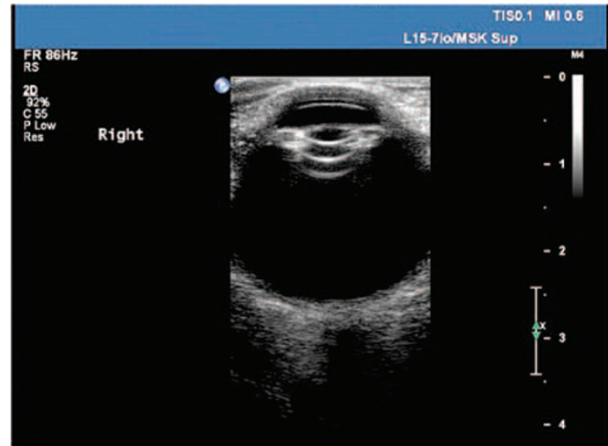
Ultrasound imaging showing a lens in the inferior vitreous.
